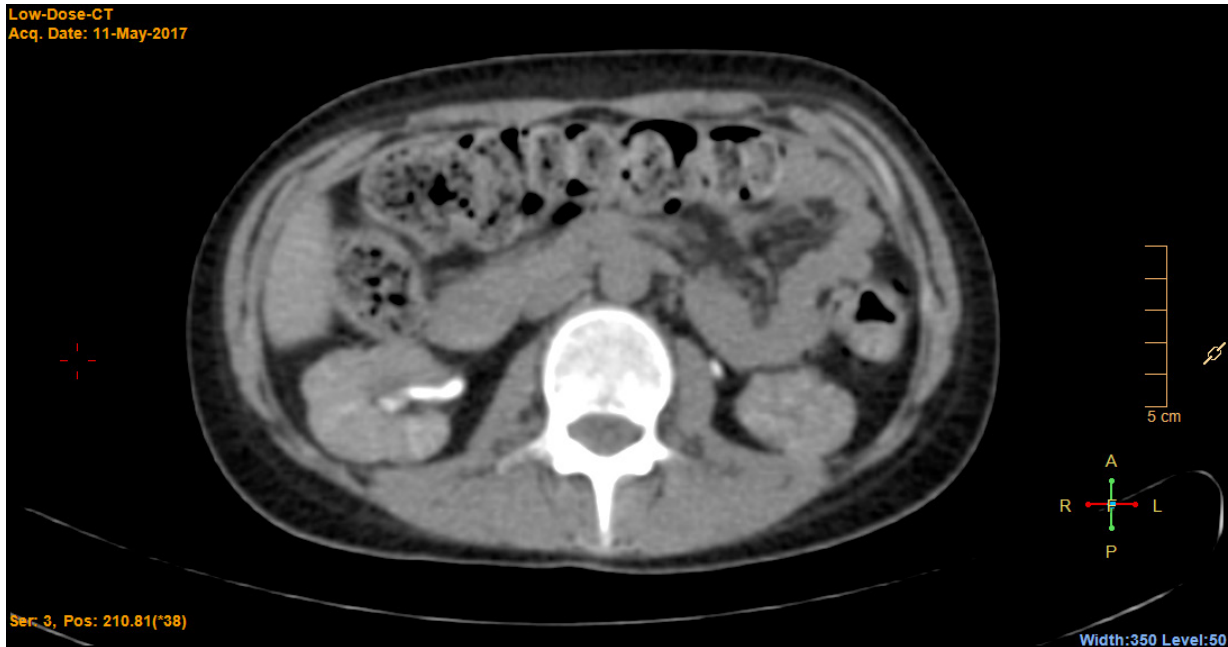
Iodine contrast is present in the right kidney (maximum value on the CT scan is about 400 HU).
